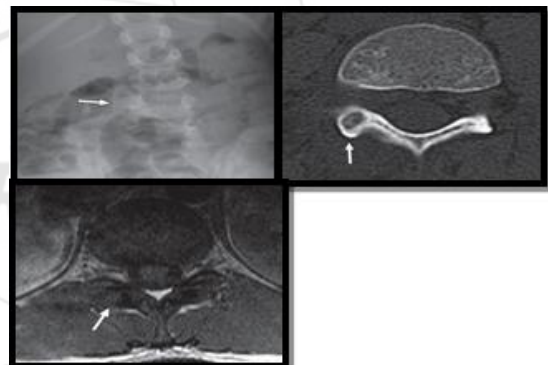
(Case 1) AP radiograph of the L-S spine showing left convex scoliosis with subtle sclerosis over right aspect of L4. CT & T1W MR images showing a nidus in L4 right inferior facet with mild surrounding sclerosis.
